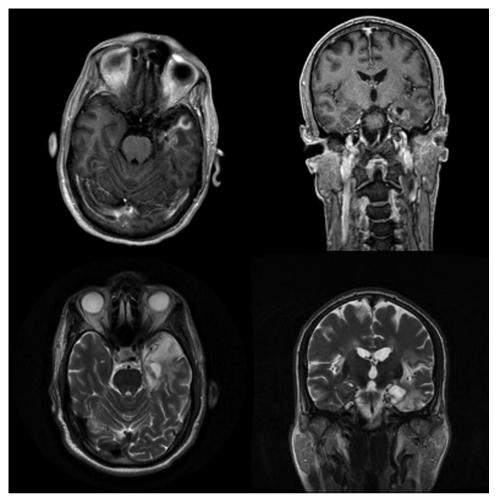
Herpes simplex encephalitis. MRI brain at one month (top left, top right) and one year (bottom left, bottom right) following the initial presentation. T1 with contrast axial (top left) and coronal (top right) images taken one month after the initial presentation showing enhancement in the left temporal lobe and subinsular cortex as well as signal abnormality in the right and left insular cortices. T2 without contrast axial (bottom left) and coronal (bottom right) images taken at one year when the patient presented with transient recrudescence of his symptoms.
